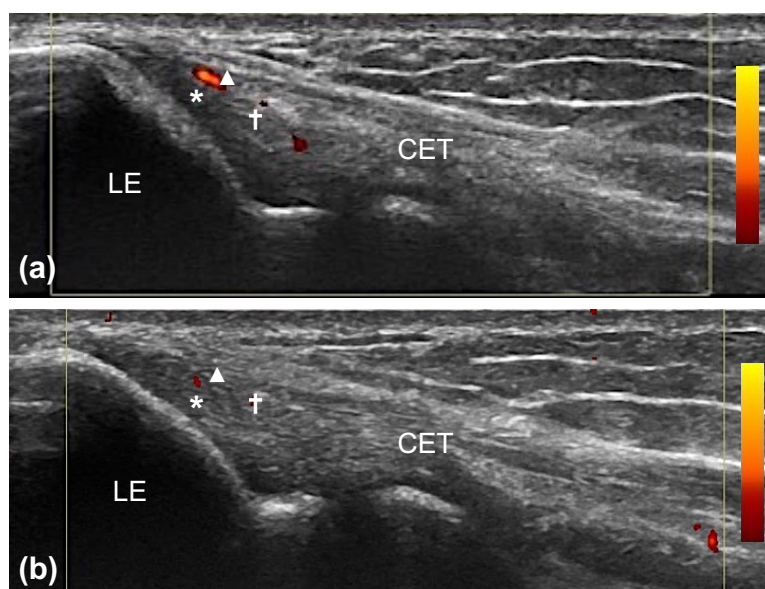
Reduction in enthesal thickness (†, grade 1 to 0), hypoechogenicity (★, grade 2 to 0) and power doppler signal (▲, grade 2 to 1) within the right common extensor tendon enthesis between week 0 (a) and week 52 of ustekinumab therapy (b). CET: Common extensor tendon; LE: Lateral epicondyle.
